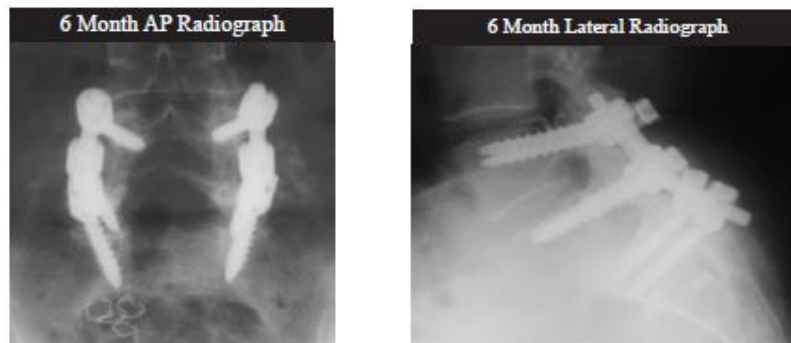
Radiograph imaging of MD
